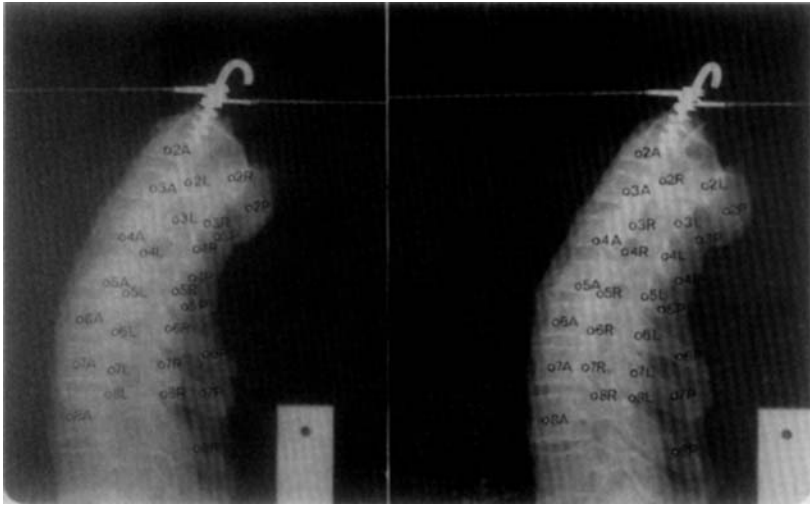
Top view. Measuring points indicated on radiograph. Bottom view. Sketch of same radiograph, where measured distances are indicated. N.B. $y' = y''$.
